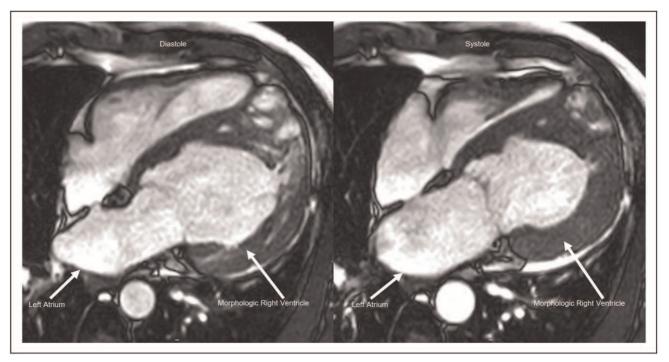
Dilated systemic right ventricle with dysfunction. Still images at end diastole and end systole from cardiac MRI steady-state free precession imaging of a 37-year-old with ccTGA with no associated lesions and no cardiac surgical history. Note the severely dilated and hypertrophied systemic, morphologic right ventricle on the left side of the chest, with little area change between diastole and systole compared with the right-sided, morphologic left ventricle.
